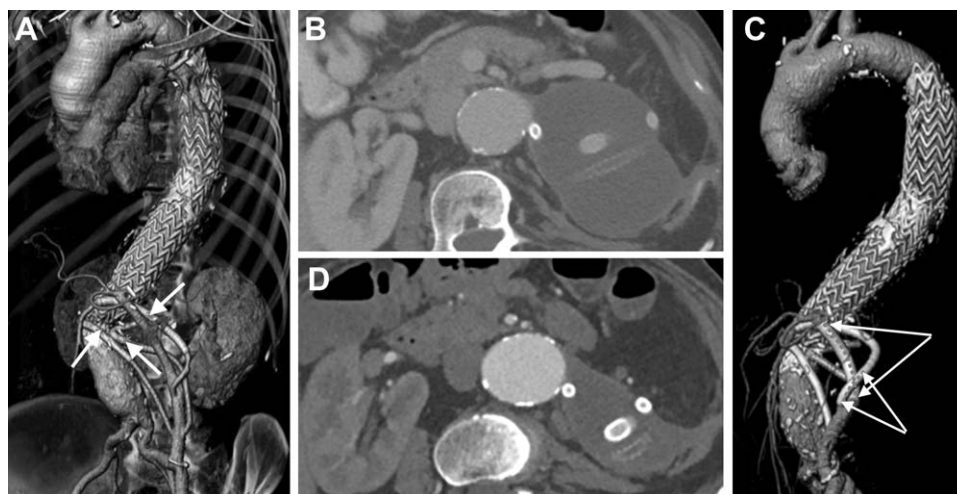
♦ (A) CT scan reconstruction showing the renovisceral bypasses. The asterisks denote the Viabahn stent-grafts used as connectors to the superior mesenteric and the left renal arteries in the VORTEC technique. (B) Perigraft seroma. (C) CT scan reconstruction showing relining (between arrows) of the grafts to the SMA and the celiac trunk. (D) Appearance of the perigraft seroma 13 months after relining.
